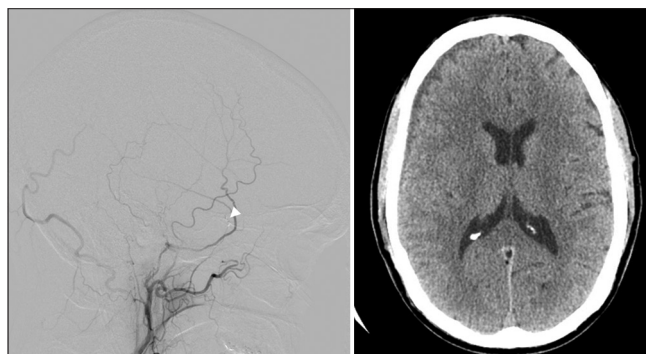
Follow-up angiogram at outside institution showing successful embolization of the lesion and the parent vessel opacified (left). Follow-up head computed tomography at outside institution showing significant improvement of the right convexity subdural hematoma (right).
